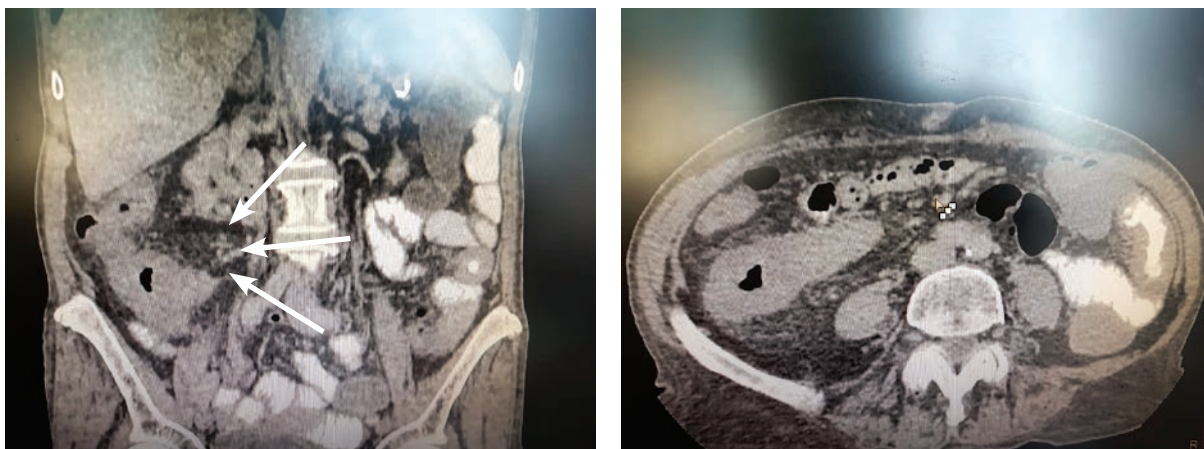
CT scan. The arrows indicate the thickening of the wall of the ileum and ascending colon, inflammatory infiltrated tissue
